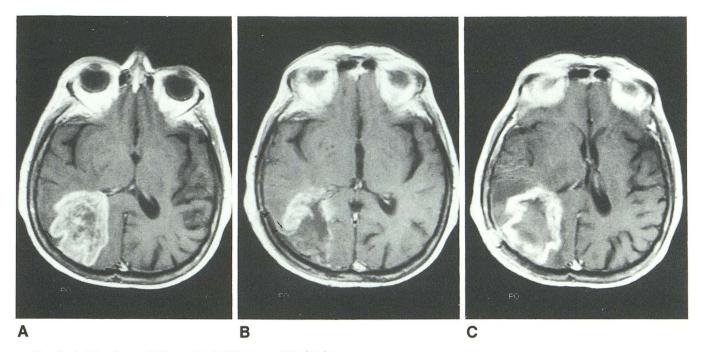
Axial enhanced T1-weighted MR image (600/20/2) obtained preoperatively (A), on second day (B), and 2 weeks after extirpation of a glioblastoma (C).
